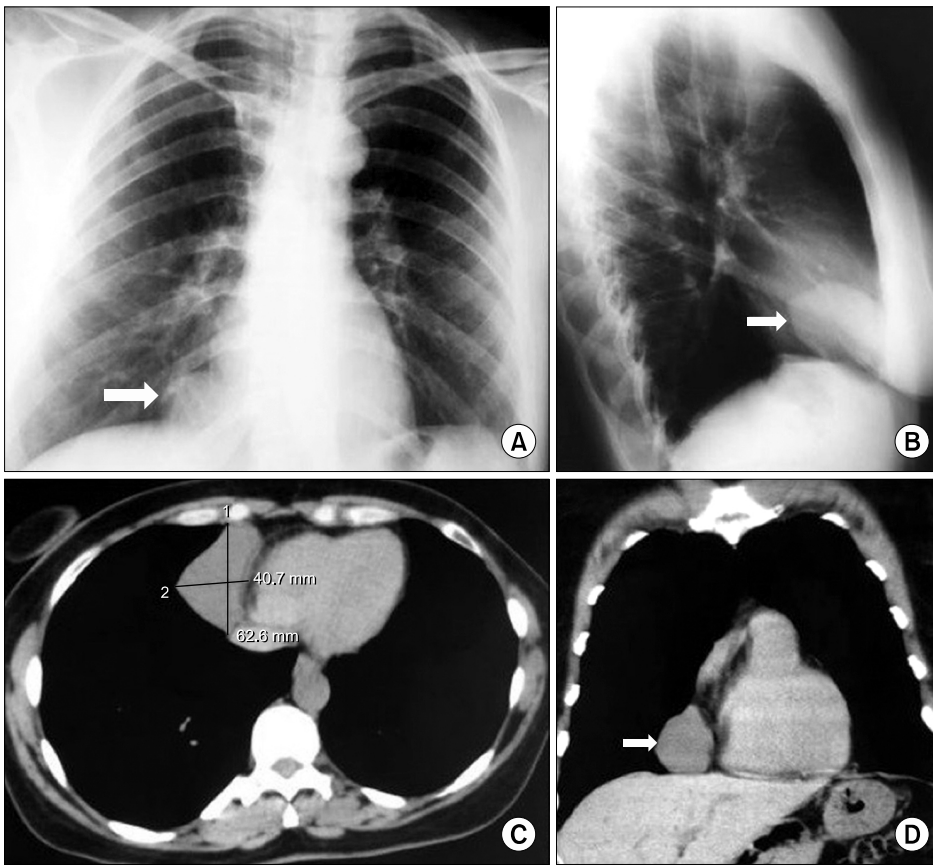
(A) A posteroanterior chest X-ray revealed an opacity on the lower right border of the heart (arrow). (B) A right lateral-view chest X-ray localized the opacity in the middle mediastinum (arrow). (C) Axial and (D) coronal thoracic computed tomography scans showed a pericardial cystic lesion that measured 40.7×62.6 mm (arrow). This lesion abutted the chest wall and right pericardium. No pericardial effusion or mediastinal lymphadenopathy was evident.
